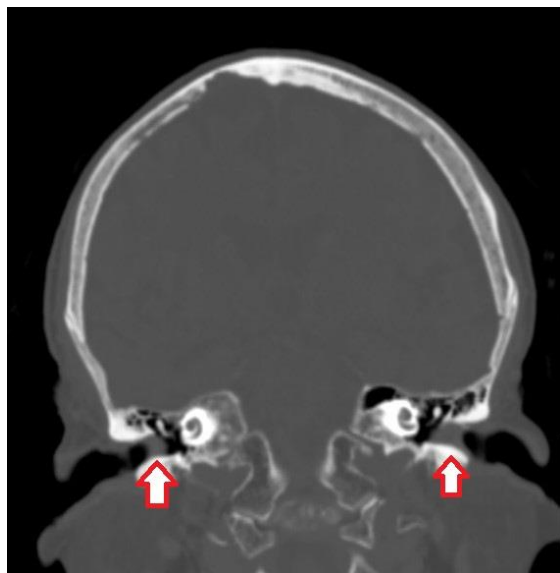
CT of a brain without contrast in the bone window showing fluid within the bilateral external ear canals (arrows), with a HU of 40–80, which indicates the presence of blood.
